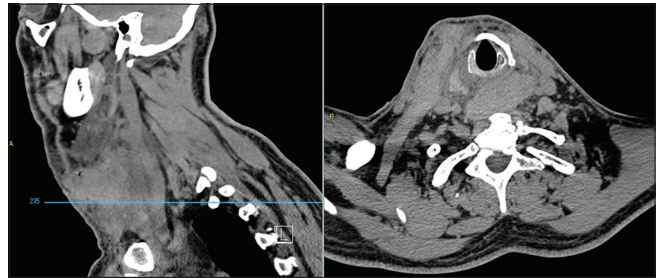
Sagittal (left) and axial (right) CT scan sequences showing a significant right laterocervical and retrotracheal hematoma determining compression of the upper aerodigestive structures.
